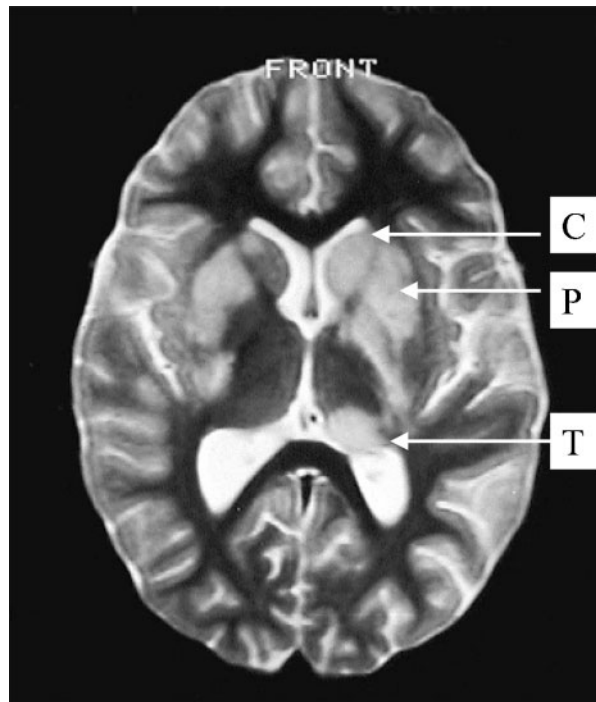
Post-streptococcal encephalitis presenting with dystonia and behavioural alteration. MRI brain T2 weighting, demonstrating inflammatory changes in bilateral caudate nuclei (C) bilateral putamen (P) and thalamus (T).
